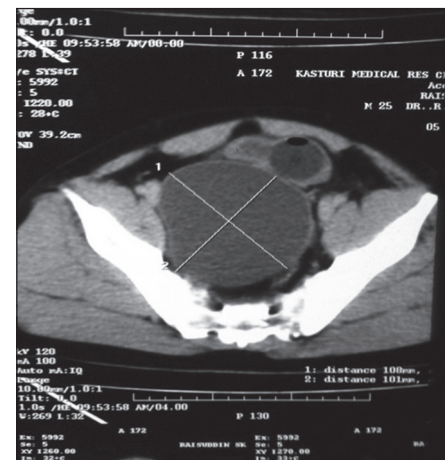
Contrast-enhanced computed tomography of abdomen showing the cyst within pelvis in relation to the rectum and urinary bladder
